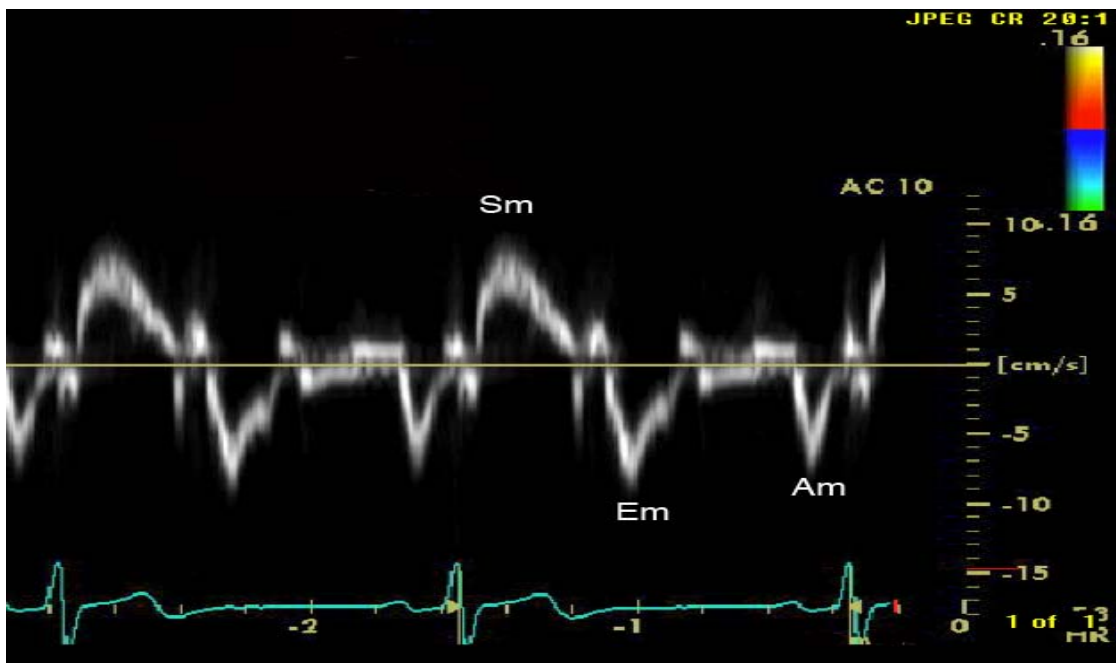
A normal pulsed-wave tissue Doppler trace acquired at mitral valve annulus; Sm, peak systolic mitral annular velocity; Em, peak early diastolic mitral annular velocity; Am, peak mitral annular velocity associated with atrial contraction.
